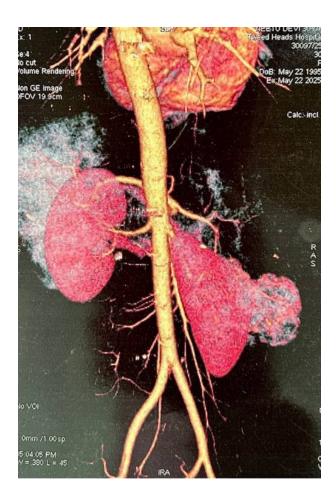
CT renal angiography – Large well defined smoothly marginated heterogenously enhancing exophytic mass is seen arising from mid pole of right kidney measuring "7.4 x 5.1 cm" with necrotic areas(white arrow). No calcification is seen. No fat density is seen. It is bulging into perinephric fat and extending superiorly. No extension seen beyond Gerota's fascia. Right renal vein and IVC are normal. Ipsilateral left adrenal gland is normal. It is abutting inferior surface of right lobe. It is indenting right renal vessels with contact angle of 180°.
